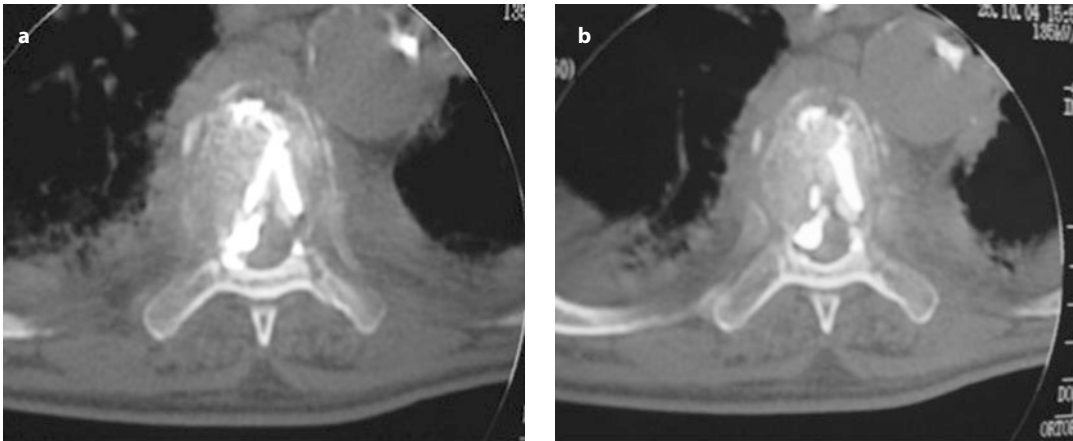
79-year-old female with an acute vertebral porotic fracture at the T8 level. Axial CT control at the T8 level shows endocanal leakage of cement due to an incorrect unipedicular approach (a and b)
